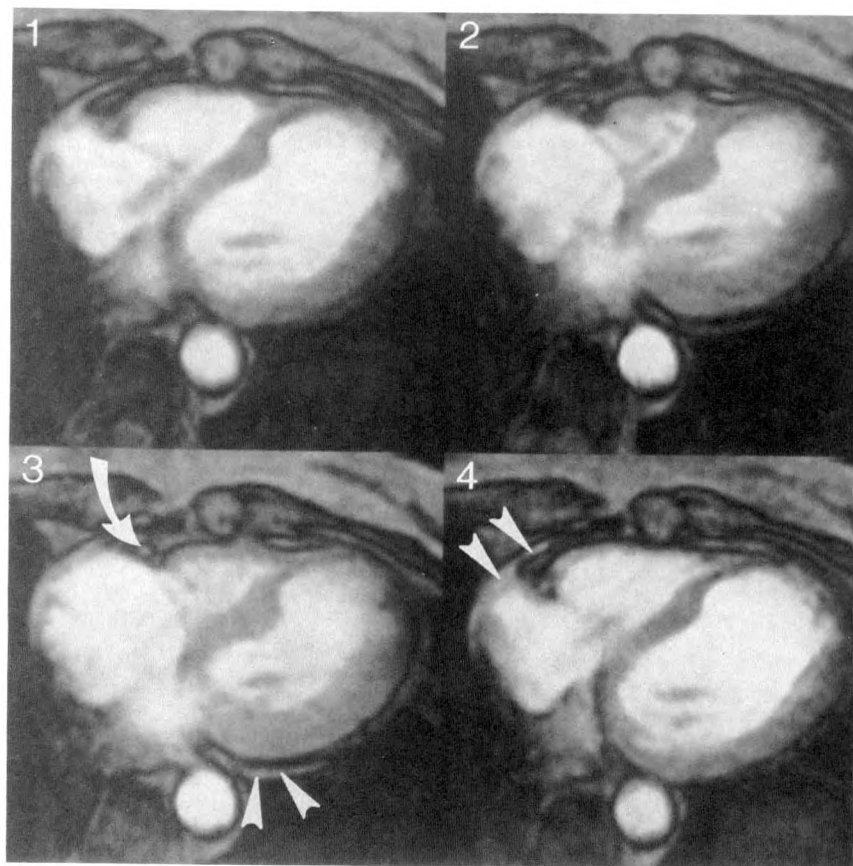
Transverse cine MR images through heart of patient with 3-month-old anteroseptal myocardial infarction. Image 1 was obtained in early systole, image 2 further into systole, and image 3 at end systole. Image 4 represents late diastole. Note absence of wall thickening in anteroseptal region and localized hypertrophy of mid-septal area. Damaged myocardium is sharply demarcated from normal myocardium. A small pericardial effusion with high signal intensity is visible over right atrium and behind left ventricle (arrowheads, images 3 and 4). Note right coronary artery within right atrioventricular groove (curved arrow).
